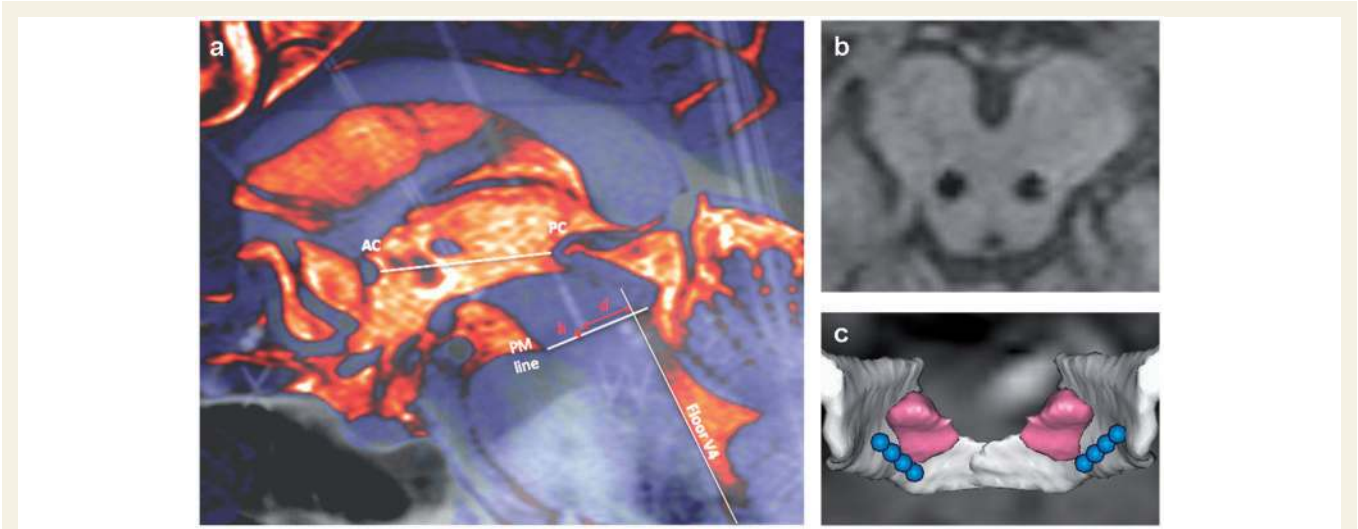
Location of the electrodes in the pedunculopontine area for Patient 1. (a) Sagittal fusion imaging of the final intra-operative teleradiography with the preoperative MRI, showing how the coordinates of the tip of the distal contacts of the electrodes were measured. h: distance (in mm) to the pontomesencephalic (PM) line, defined as the line connecting in the anterior-posterior direction the pontomesencephalic junction to the caudal end of the quadrigeminal plate, measured on the midline; AC: anterior commissure; PC: posterior commissure. d: orthogonal distance in mm to the line prolonging the fourth ventricle line. V4: fourth ventricle. (b) 3D T₁-weighted magnetic resonance imaging in the axial plane parallel to the bicommissural plane, at the level of contacts 1 and 5 of the electrodes. Those contacts delivered cathodic current and the contact depth of the right and left electrodes was symmetrical. (c) Atlas adaptation onto patient's MRI (Yelnik et al., 2007). Superior posterior view of the 3D image with the pedunculopontine nucleus in pink, the medial lemniscus in white and the four electrode contacts in blue. Note that in this patient the electrode is located posterior to the pedunculopontine nucleus.
